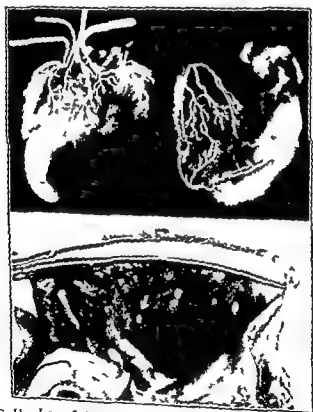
Upper Left Roentgenogram of heart in which the four major anterior cardiac veins have been cannulated and injected with contrast medium. Anterior view. Upper Right Roentgenogram of heart in which three branches of one anterior cardiac vein have been injected. Anterior view. Lower Photograph of interior of right atrium showing the position of four major anterior cardiac vein openings with plugs of injection material remaining after removal of cannulae. The arrow points to the opening of the vein which drains the pulmonary conus region. (Gregg et al.)
